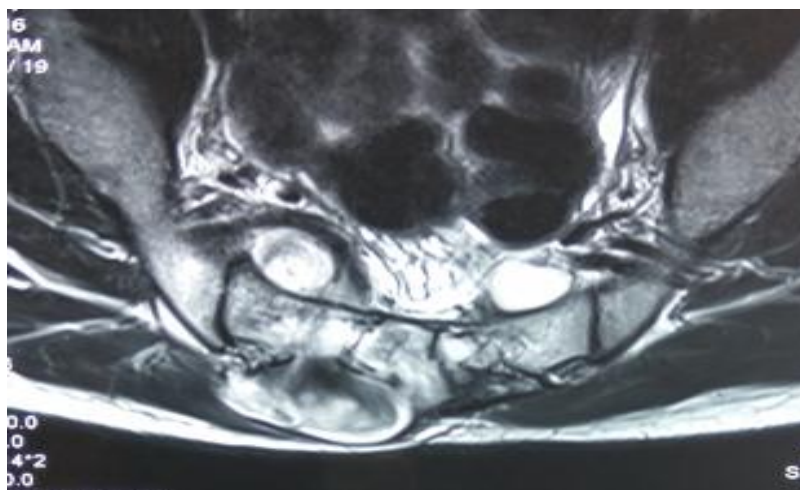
Axial MRI showing sacral mass with extension posteriorly
